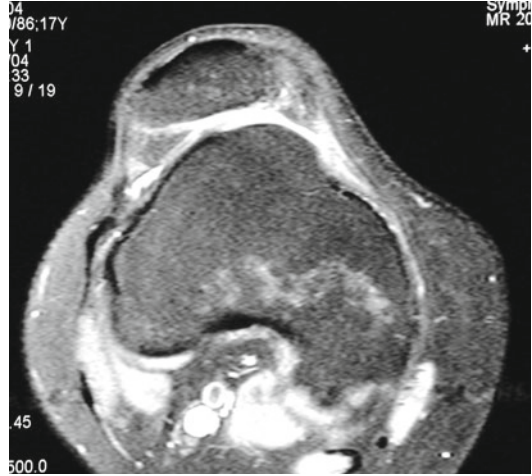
Central bump with severe patellar subluxation (*axial MRI*)
